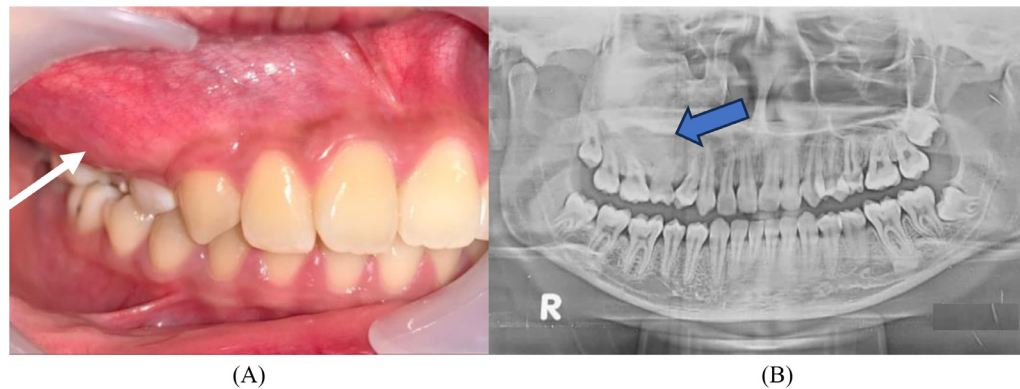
Ossifying fibroma. (A) The intraoral picture shows a lump in the right maxillary region, (b) orthopantomography.
